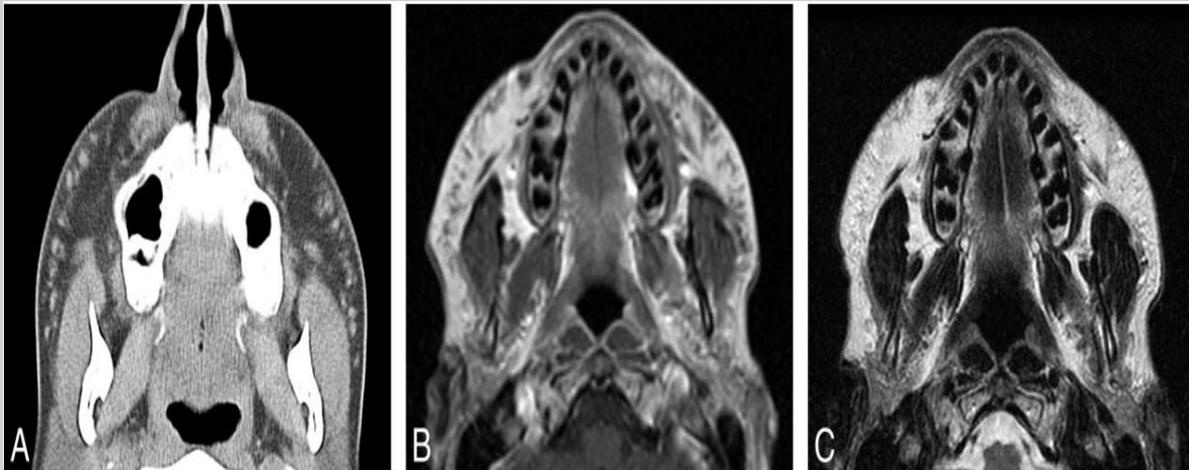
Axial CT image (A) shows multiple foci of high attenuation in the bilateral cheeks. Axial MR images in T1 (B) and T2 (C) sequences demonstrate corresponding intermediate signal intensity in both sequences.
